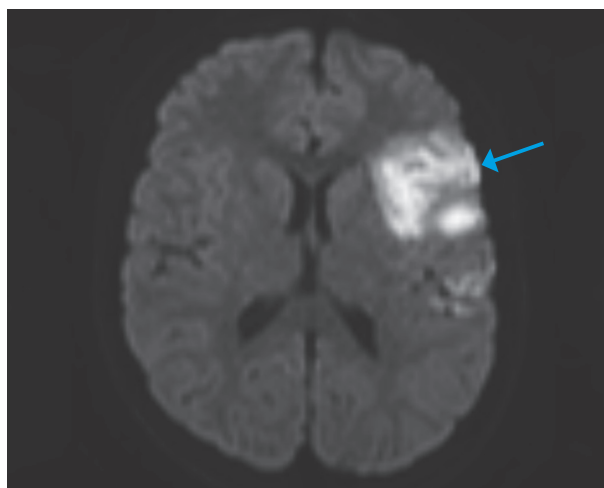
Axial diffusion-weighted magnetic resonance image shows ischemia in the territory of the left middle cerebral artery.
